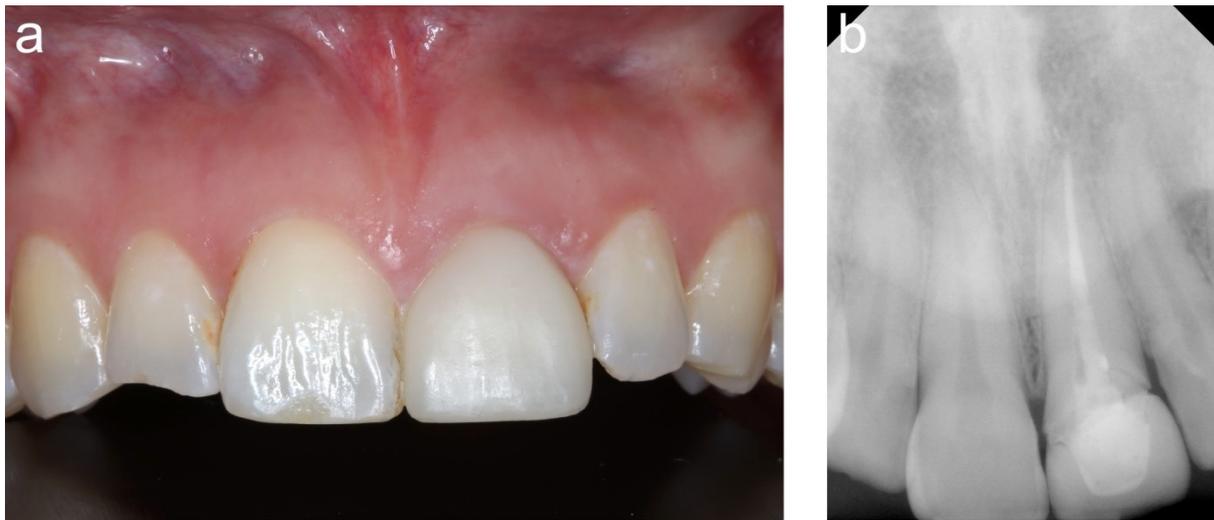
Baseline clinical and radiographic appearance. 1a Tooth #9 presented with a provisional crown exhibiting open margins. The facial gingiva displayed slight marginal erythema and edema. 1b A poorly fitting post was present within the canal space.
